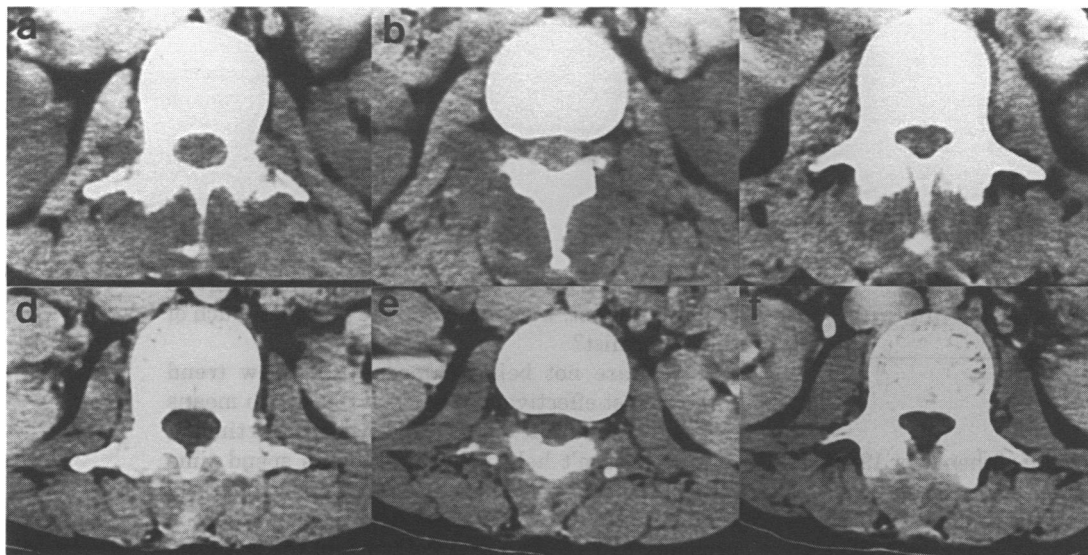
CT lumbar spine. Pre-treatment scans (plain) at (a) L2, (b) L2/3 and (c) L3 levels showing bone erosion of transverse processes of the L2 vertebra and spinal laminae, as well as abscess formation in the paraspinal muscles. Post-treatment scans (contrast-enhanced) at corresponding levels (d), (e) and (f). The hypodensities in the paraspinal muscles are no longer evident and bone erosion is arrested
